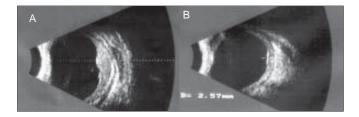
(A) Ultrasound showing the elevated nodular component of diffuse choroidal haemangioma before treatment. (B) Regression of the nodular component 1 month after treatment
